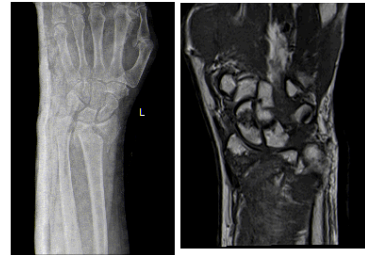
Scaphoid Fracture diagnosed on MRI
